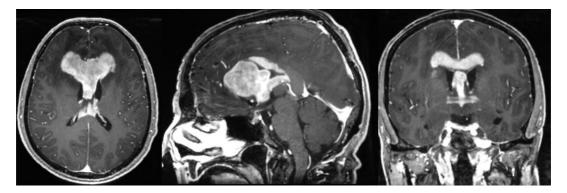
Post-contrast T1W images showing lymphomatous involvement of CNS. Leptomeningeal infiltration may manifest on MR images as a diffuse thickening or focal enhancing masses of the ependyma, meninges, or cranial or spinal nerves⁵⁷.
